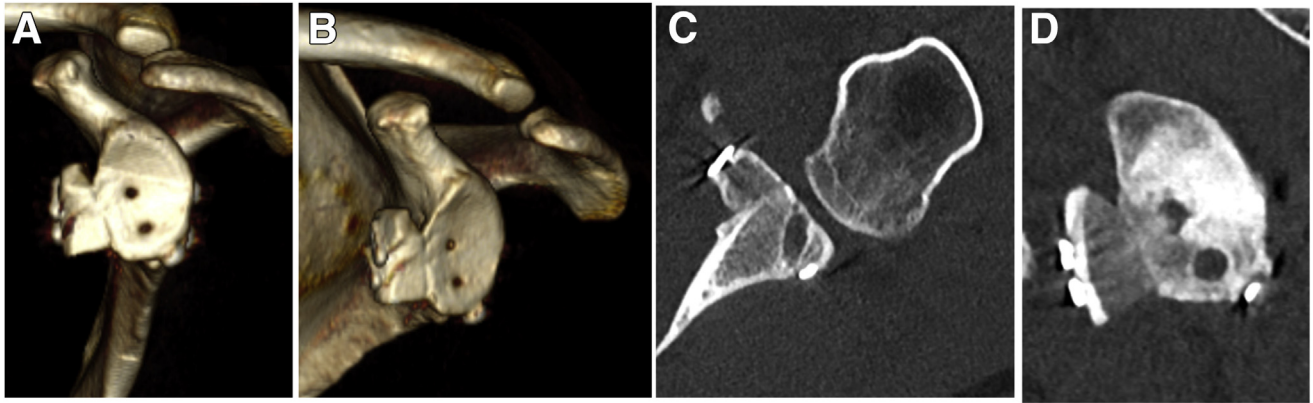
(A-B) Three-dimensional computed tomography (CT) reconstruction showing optimal position of the bone graft (subequatorial and flush to the glenoid rim). Axial (C) and sagittal (D) views of CT scan showing bone graft healing.
